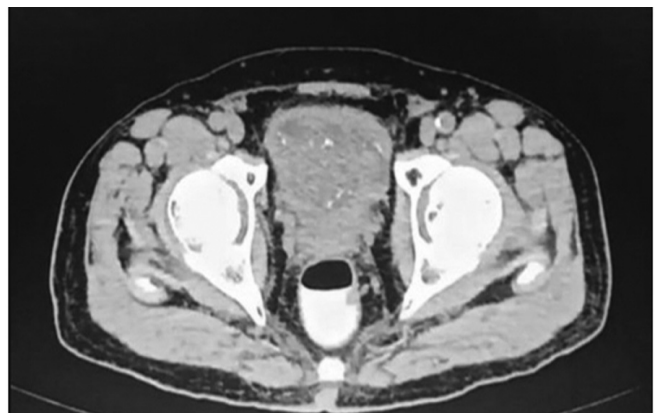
CT scan abdomen axial view.
